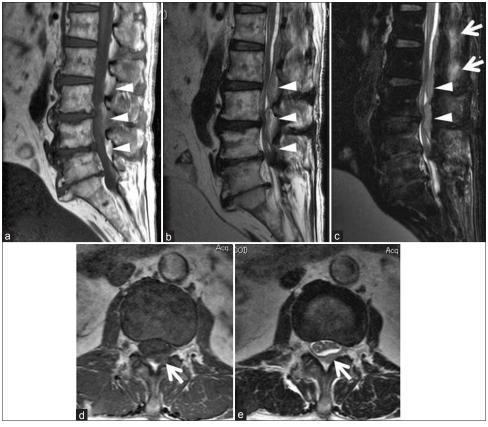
An epidural mass was observed as a mildly hyper-intense signal on the T1-weighted (a), iso-intensity signal on the T2-weighted (b), and a mildly hyper-intense signal on the fat-suppressed T2-weighted image (c, arrowheads). Furthermore, mildly hyper-intense signals in the posterior ligament complex on the fat-suppressed T2-weighted image indicated the presence of aging blood (c, arrows). On axial view (L2–L3 disk level), a mixed intensity signal on the T1-weighted (d) and an iso-intensity signal on the T2-weighted image (e) was shown to compress the dura (arrows)
